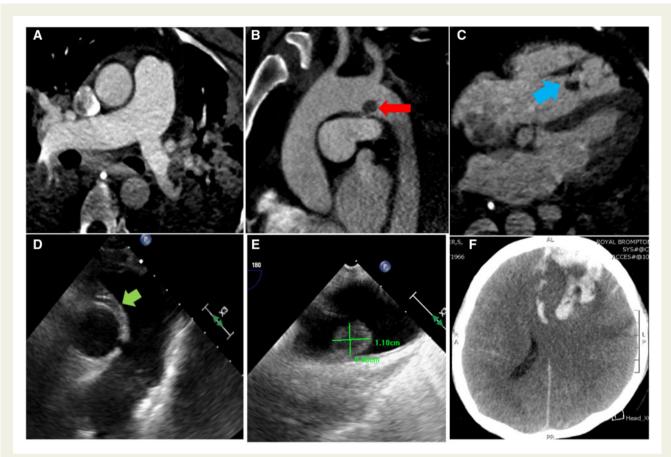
Figure I Case 1. Computed tomography images demonstrate pulmonary thrombosis in left main pulmonary artery (A), thrombus in aortic arch (red arrow) (B), low density structures inside right ventricle cavity suggestive of possible thrombus (blue arrow) (C), and massive left frontal cerebral haemorrhage (F). Transoesophageal echocardiogram images showing laminar thrombus adherent to wall of main pulmonary artery (green arrow) (D) and sessile thrombus (1.10 cm \times 0.9 cm) attached to the anterior wall of aortic arch (E).
